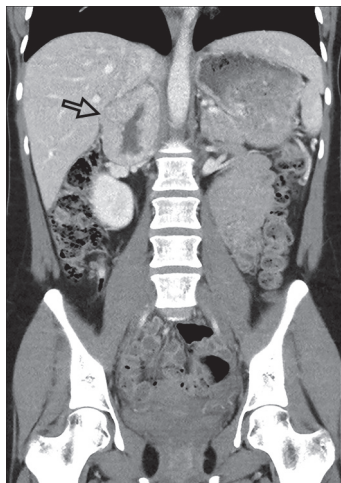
CT w/ contrast postpartum: heterogenous, peripherally enhancing, centrally necrotic right adrenal mass measuring 7.8 x 6.0 x 5.5 cm, located between the infrahepatic inferior vena cava and suprarenal abdominal aorta
